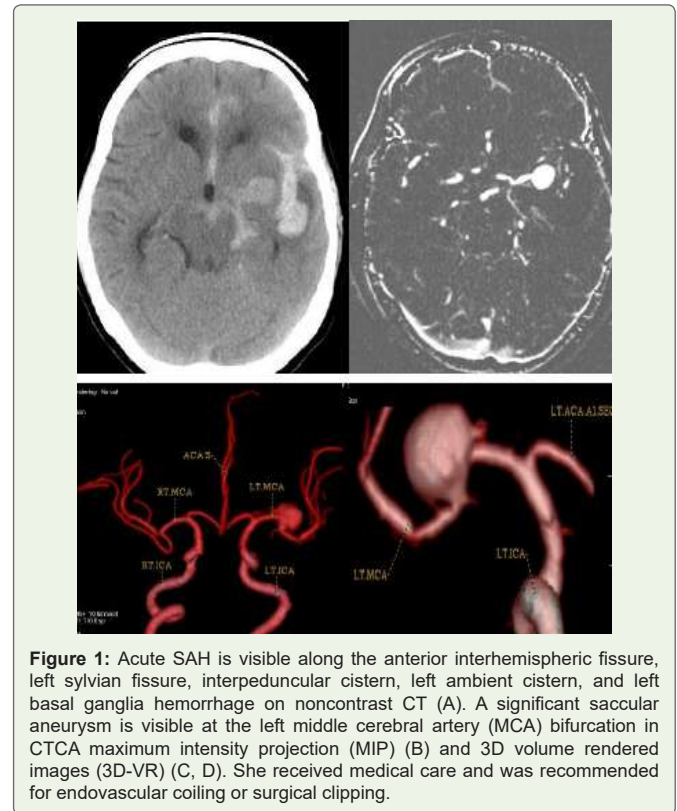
Acute SAH is visible along the anterior interhemispheric fissure, left sylvian fissure, interpeduncular cistern, left ambient cistern, and left basal ganglia hemorrhage on noncontrast CT (A). A significant saccular aneurysm is visible at the left middle cerebral artery (MCA) bifurcation in CTCA maximum intensity projection (MIP) (B) and 3D volume rendered images (3D-VR) (C, D). She received medical care and was recommended for endovascular coiling or surgical clipping.
